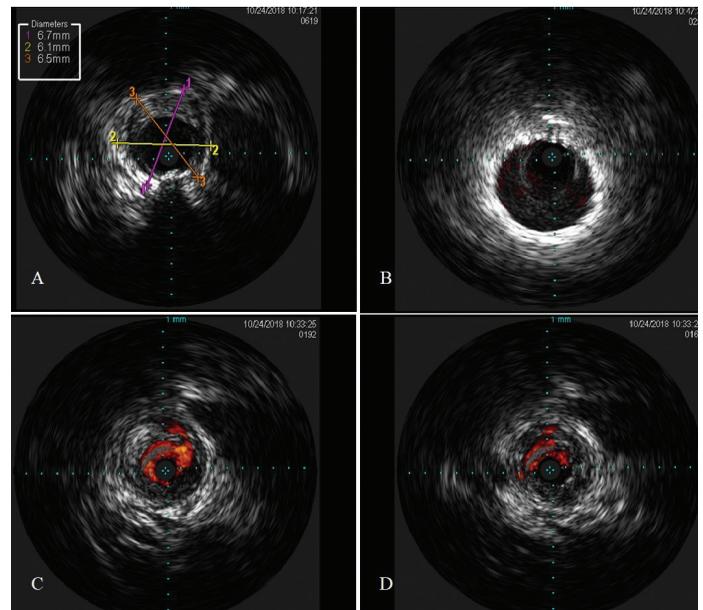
(A) Baseline intravascular ultrasound image (measurements indicate external elastic lamina to external elastic lamina). (B) Post stenting. (C) First dissection (intimal). (D) Second dissection (intimal).
